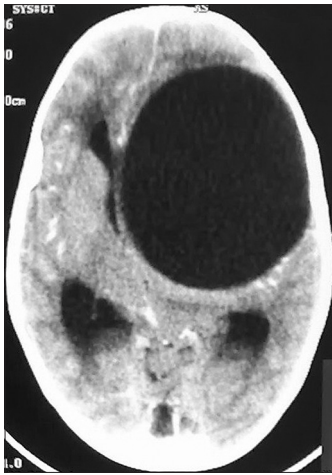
CT scan head showing a huge frontoparietal cystic lesion (hydatid cyst) in the brain
